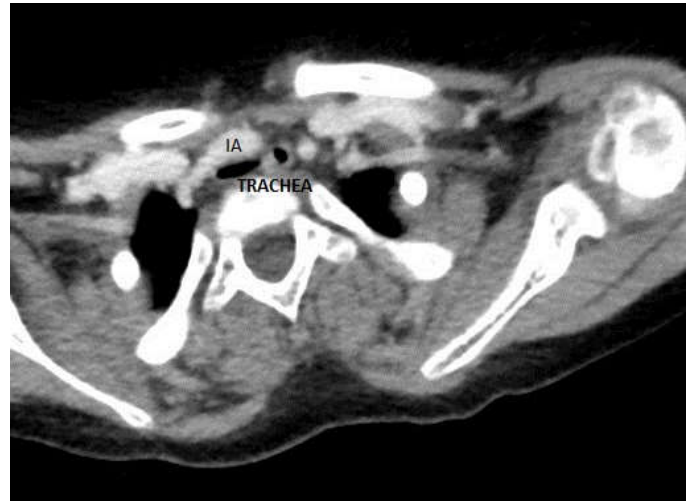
CT chest with contrast, axial cut, showing innominate artery (IA) compression the trachea
